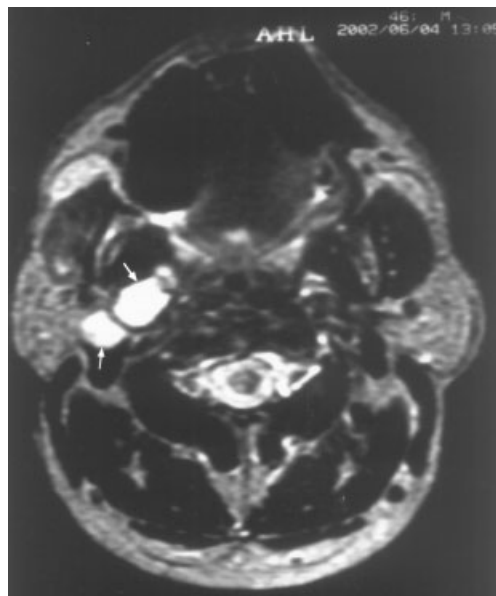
Six-month follow-up magnetic resonance imaging shows multiple masses and contrast material in the right prestyloid parapharyngeal space.
